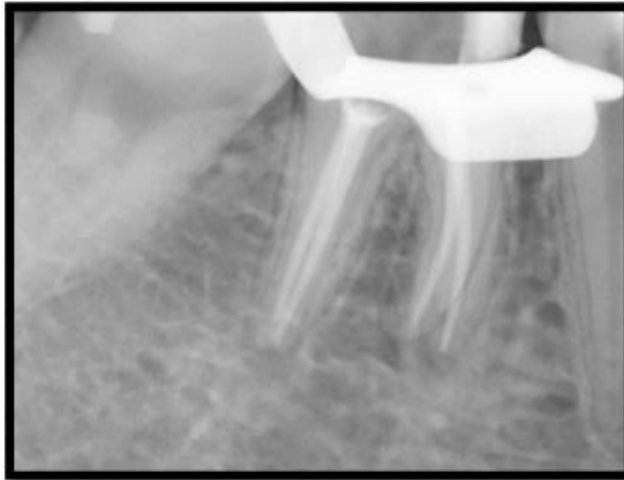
Radiograph showing obturation of #46
